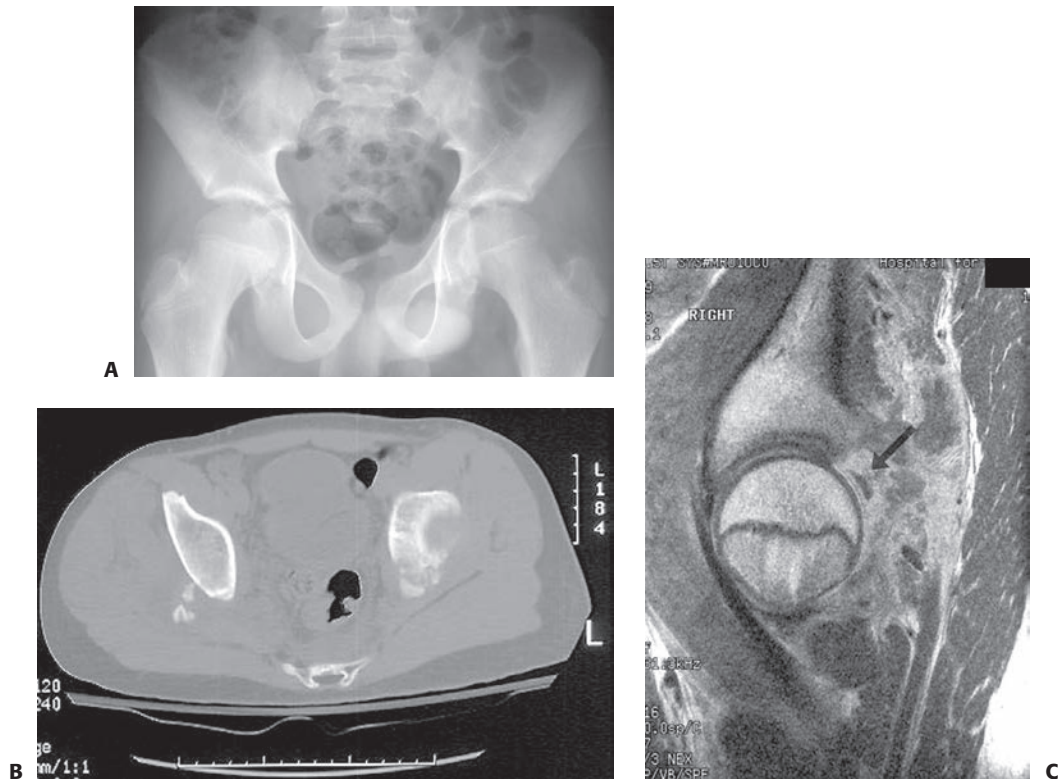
A: Postreduction radiograph of a left hip dislocation in a 12-year-old boy. B: CT scan demonstrates small ossified posterior wall fragments. C: Sagittal MRI demonstrates 90% posterior wall involvement with intra-articular step-off (*black arrow*). (From Rubel IF, Kloen P, Potter HG, et al. MRI assessment of the posterior acetabular wall fracture in traumatic dislocation of the hip in children. *Pediatr Radiol.* 2002;32(6):435–439, with permission.)
